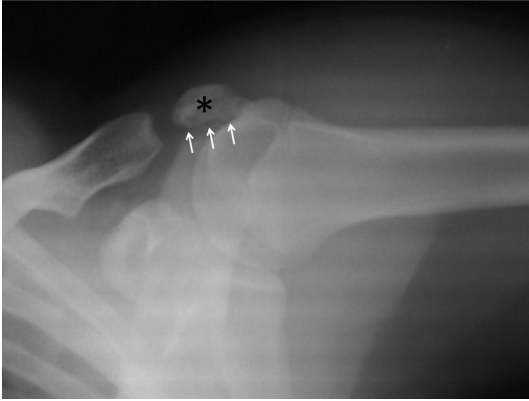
Lateral x-ray of shoulder, os acromiale was shown with arrow.
